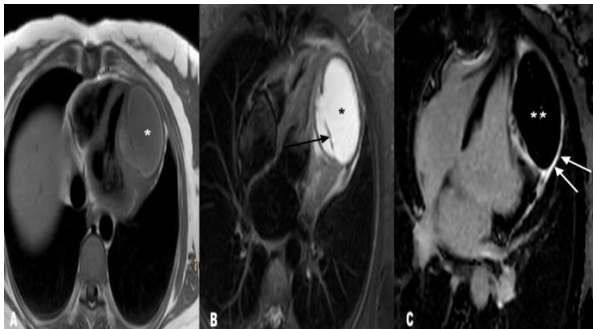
Postoperative cardiac magnetic resonance (CMR) image. (A) The T1-weighted image shows low signal intensity (white asterisk). (B) Short tau inversion recovery (STIR) sequence (T2-weighted) reveals high signal intensity of the intramyocardial lesion (black asterisk) with internal septations (black arrowhead). (C) Phase-sensitive inversion recovery (PSIR) sequence (four-chamber view) demonstrates no late gadolinium enhancement within the lesion (double asterisk) and peripheral enhancement of surrounding tissue (white arrowhead).
